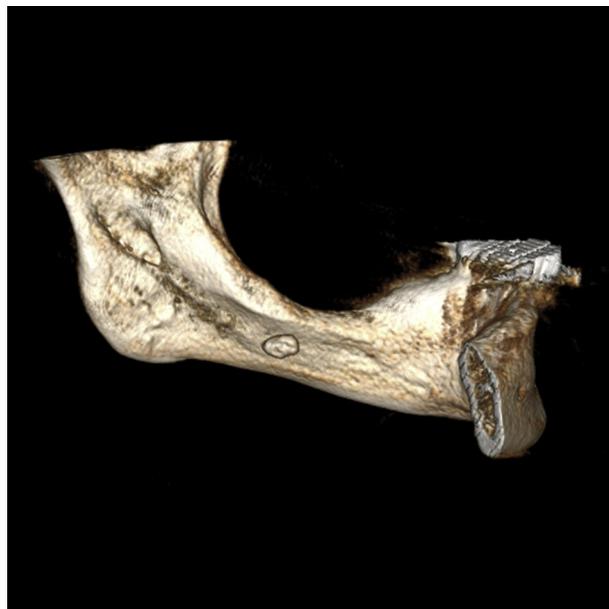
Patient 4. Cone-beam computed tomography image, 3-dimensional view of the medial aspect of the left mandible.
